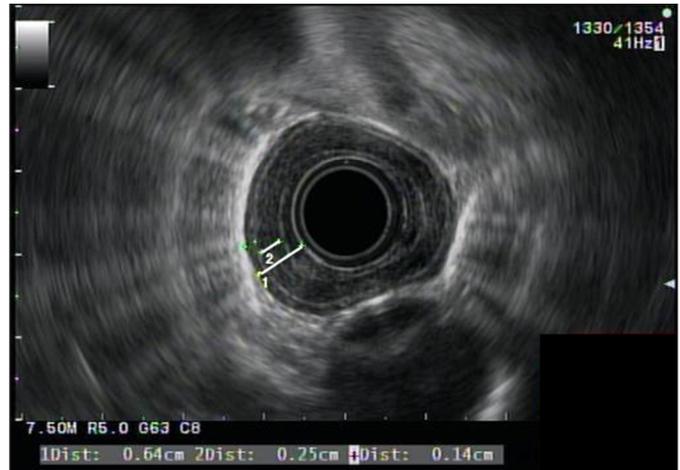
Endoscopic ultrasound showing the thickened esophageal wall (total 6.4 mm), muscularis propria layer (3.9 mm), and inner circular layer (2.5 mm).
